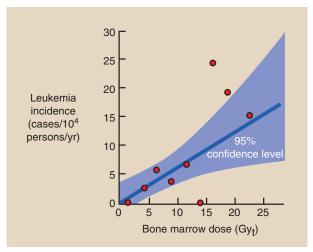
Results of observations of leukemia in patients with ankylosing spondylitis treated with x-ray therapy suggest a linear, nonthreshold dose-response relationship.
